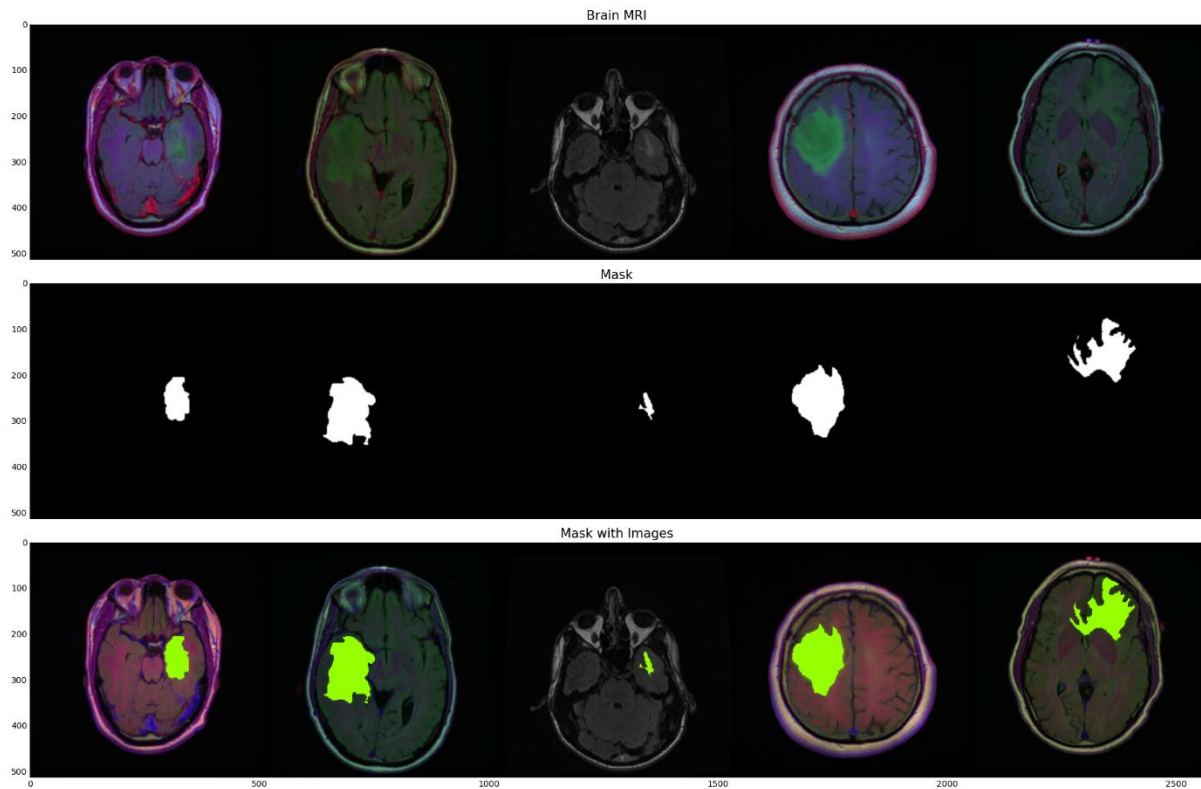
Tumor location is shown as segmented on multiple Brain MRI images
